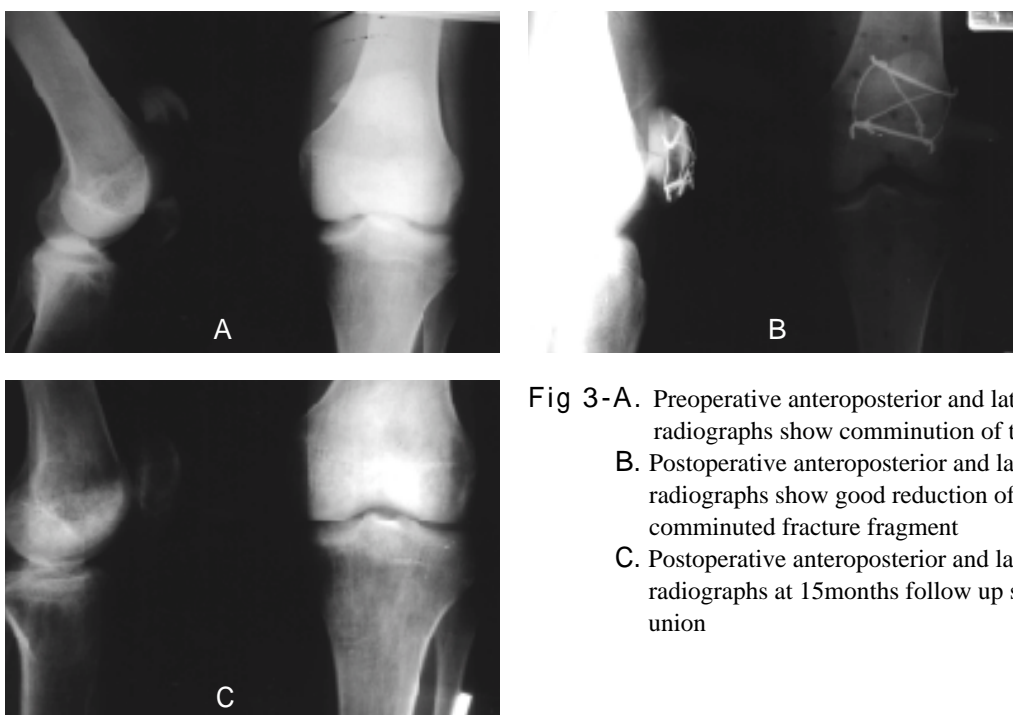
Preoperative anteroposterior and lateral radiographs show comminution of the fracture
